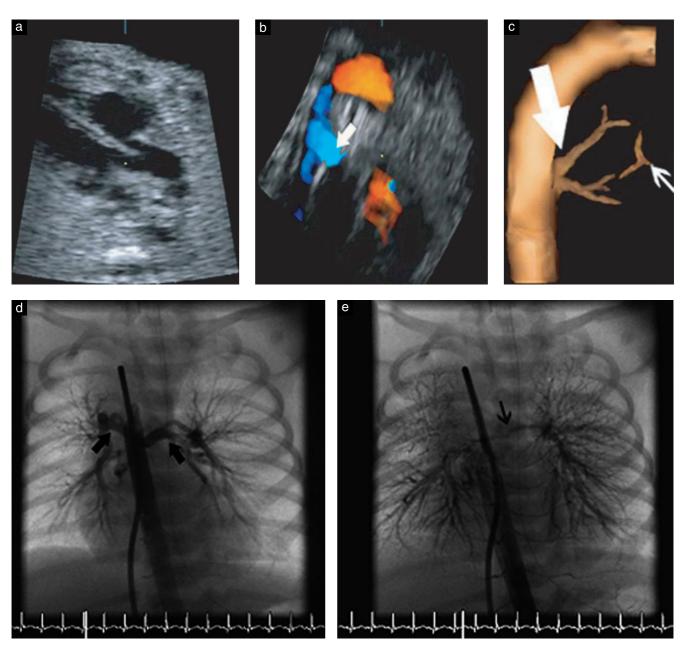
Case 10. Both pre- and postnatal echocardiography identified only the aortic outflow tract (a) and one major aortopulmonary collateral artery (MAPCA) arising by the descending aorta (b; arrow), with no evidence of confluent pulmonary arteries. This was instead demonstrated by B-flow with spatio-temporal image correlation (c), and confirmed by cardiac catheterization (d, e), along with the presence of a second MAPCA that had been missed on two-dimensional sonography. In (c) the large arrow indicates the MAPCA and the small arrow indicates the confluence of the pulmonary arteries. In (d) the arrows indicate the MAPCA. In (e) the arrow indicates the confluence of the pulmonary arteries.
